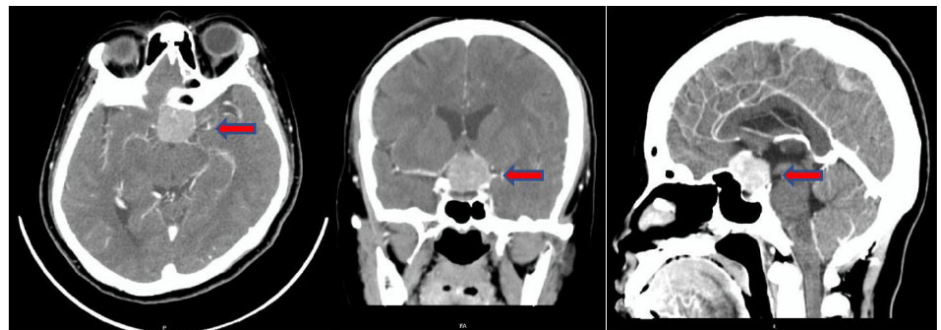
CT-Scan examination showed solid mass with inhomogeneous contrast enhancement measure in sella-suprasella appeared obliterating bilateral optic chiasm mostly in the left side, suggest macroadenoma.
